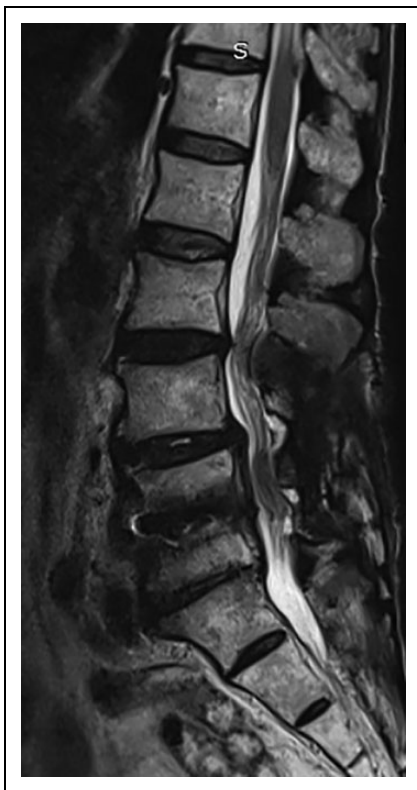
Mid-sagittal magnetic resonance image of patient at 8-month follow-up.
